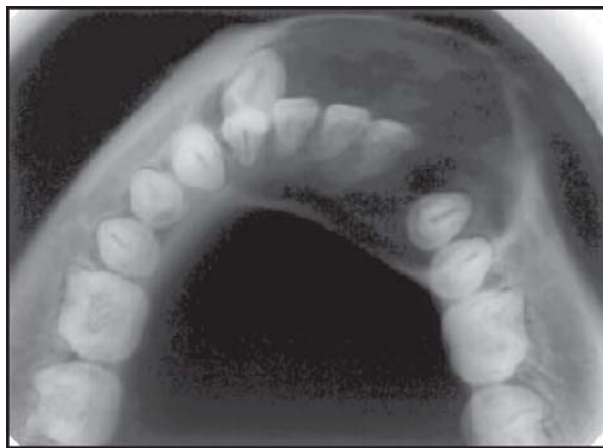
Occlusal radiograph showing AOT
